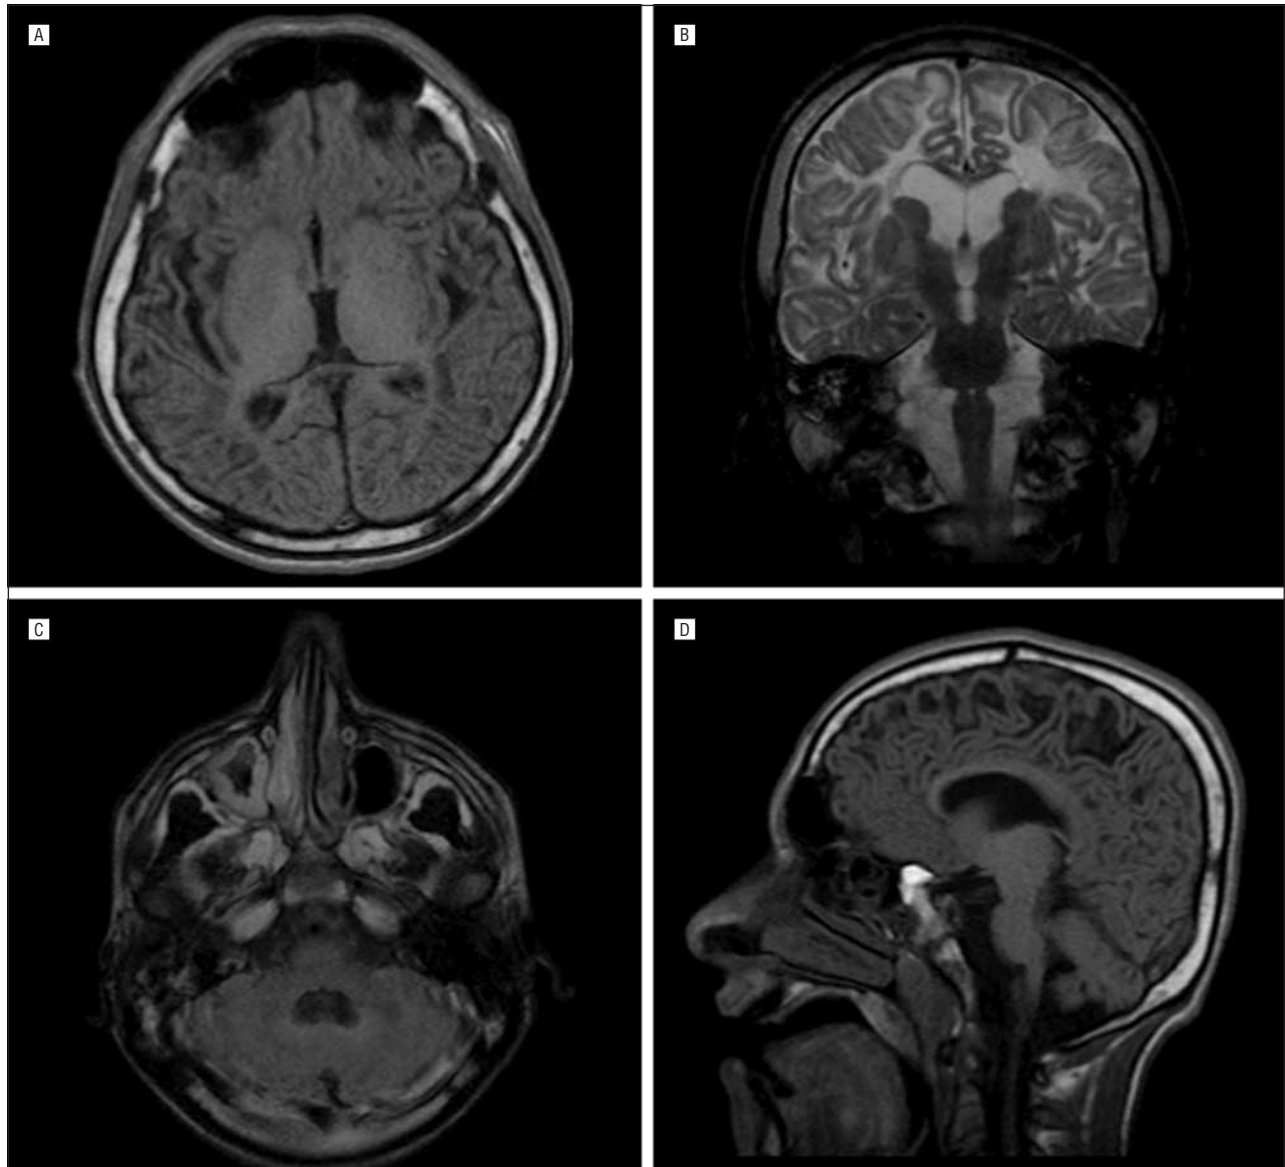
Magnetic resonance images of the brain. A, Axial T1-weighted image showing hypointense signals in subcortical white matter sparing the cortical rim. The thalamus shows a normal signal intensity. B, Coronal T2-weighted image showing hyperintense T2-weighted signal in bihemispheric white matter, prominent in the subcortical, peripheral white matter and with relative sparing of the internal capsule. No abnormal signal is observed in the caudate, putamen, pallidum, and thalami. Brain atrophy is evident, with bilateral ventricular dilation. C, Axial fluid-attenuated inversion recovery image. Posterior fossa shows normal signal intensity of the dentate nuclei. Cerebellar atrophy is not apparent, although slight dilation of the fourth ventricle is evident. D, Sagittal T1-weighted image showing hypointense signals in peripheral subcortical white matter.
